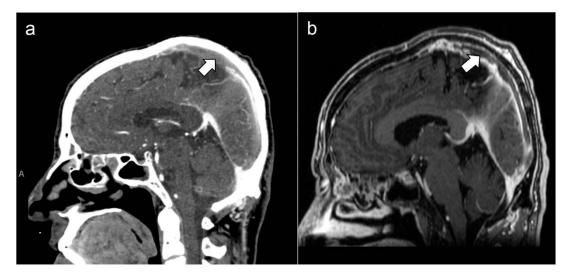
A, CT Angiogram demonstrates extensive filling defects (arrows) within the superior sagittal sinus. B, MRI Brain with contrast confirms the findings
